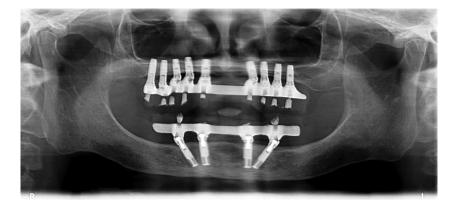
Representative orthopantomography of the same patient as in Figures 1 and 2, currently with 18 years of follow-up
